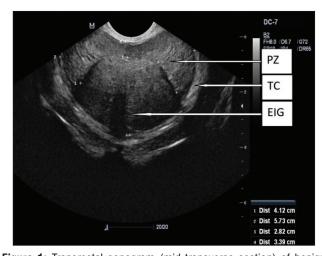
Transrectal sonogram (mid-transverse section) of benign prostatic enlargement showing the slightly compressed peripheral zone by an enlarged inner gland (EIG, Enlarged Inner Gland = central zone + transitional zone). Line 1: Transverse diameter of the enlarged transitional zone; Line 2: Transverse diameter of the whole prostate gland; Line 3: Anteroposterior diameter of the enlarged whole prostate gland. TC: True capsule
